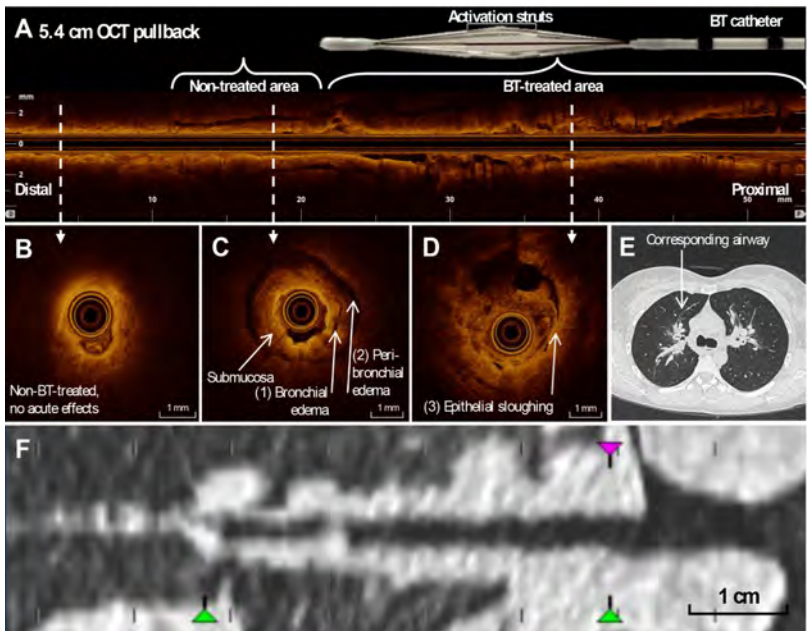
Optical coherence tomography (OCT) characteristics in comparison to computed tomography (CT) in the anterior segment of the right upper lobe (RB3) after bronchial thermoplasty (BT). a Pullback of 5.4 cm with an airway
